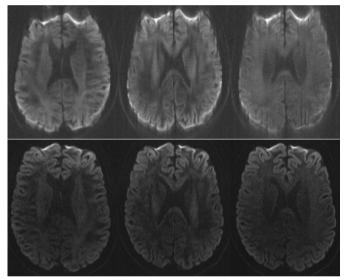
DWI along x/y/z directions; Upper: center-out EPI; Lower: standard partial-Fourier EPI.
